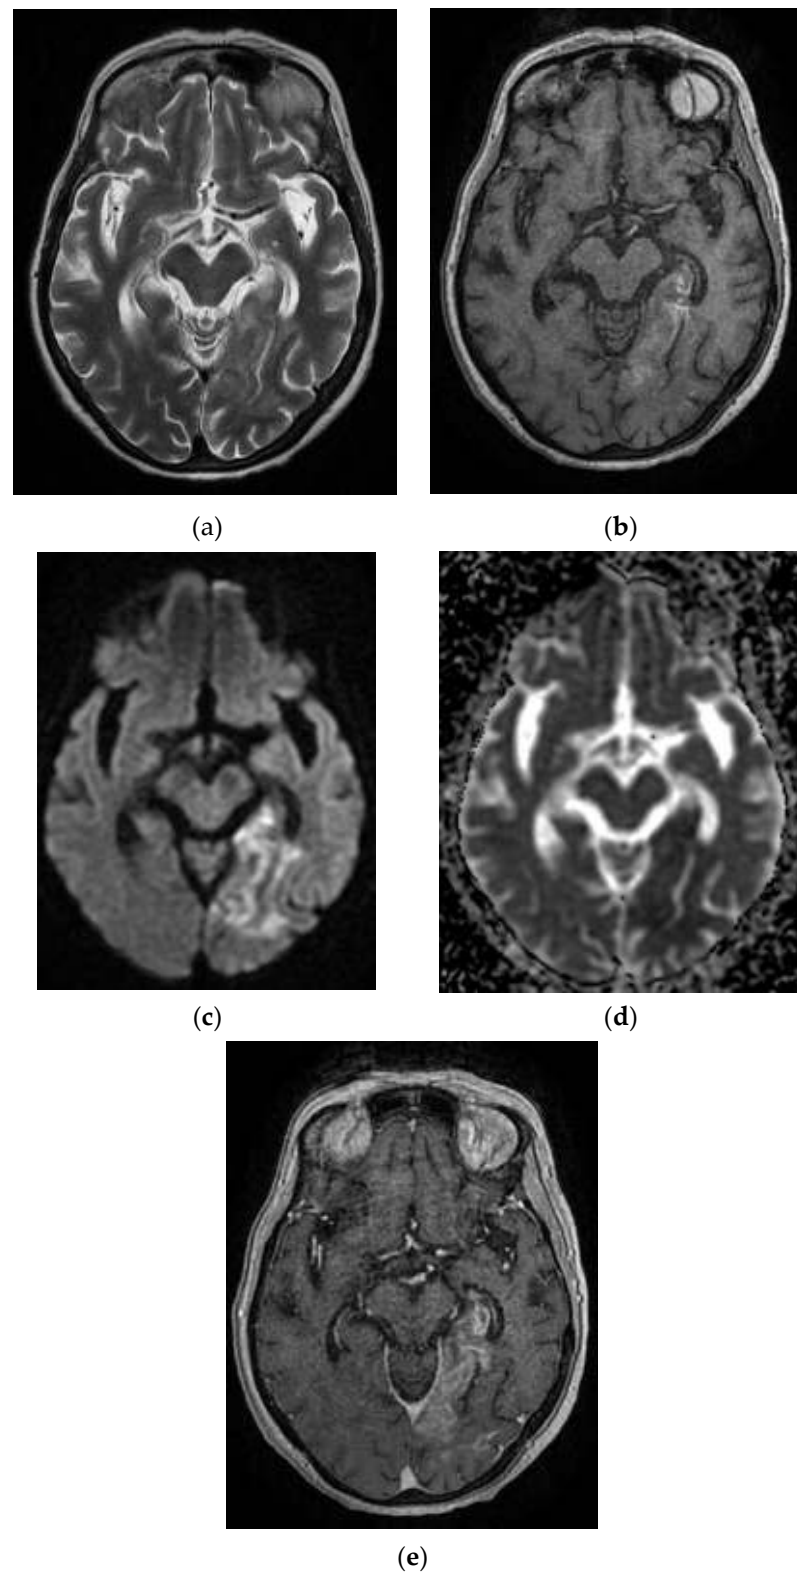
After 11 days from the first pulmonary CT, the cranio-cerebral MRI in the Case 10 patient showed foreshadowing of intense T2 signal (a), with deposits of predominantly peripheral methemoglobin (b), deficient restriction of diffusion (c,d) and gyriform gadolinium I (e), developed in the cortical–subcortical–occipital left median side with extension in the thalamic nucleus on the same part. In conclusion, infarction hemorrhagically transformed into superficial and profound territories of the left posterior cerebral artery.
